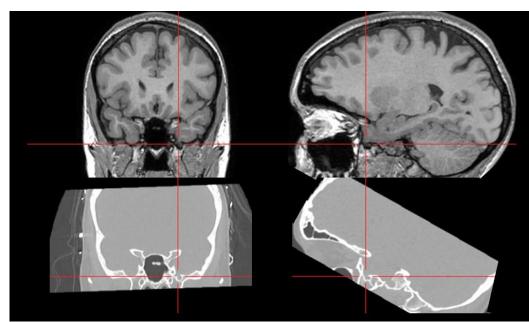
Demonstrates a small encephalocele of the anterior temporal region. The T1 SPGR has been coregistered with high-resolution CT. The cross hairs demonstrates an easily overlooked finding.
